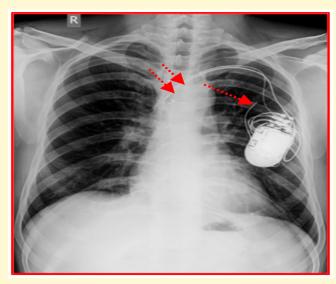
Frontal radiograph showing permanent cardiac pacemaker leads pulled and deactivated.
